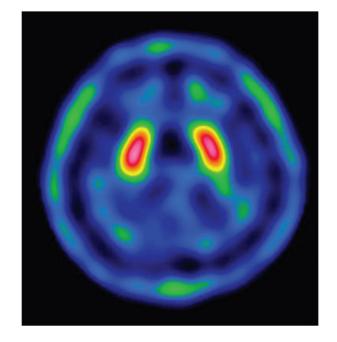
^{99m}TCTRODAT-1 SPECT scan of the patient 5 months after HAART. The ^{99m}TRODAT-1 SPECT study showed normal dopamine transporter binding in the bilateral basal ganglia 5 months after HAART.
